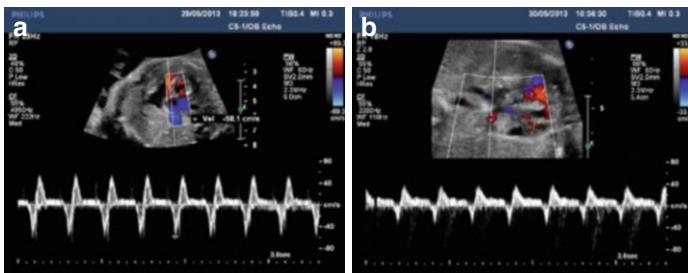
Doppler tracing of the pulmonary veins pre- and post-fetal atrial septostomy in a fetus with hypoplastic left heart syndrome and almost intact interatrial septum. (a) Pre-intervention assessment. Bidirectional flow in the pulmonary vein with high reversal flow velocity (58 cm/s) during atrial contractions (negative wave below the baseline). (b) Post-intervention assessment on the following day. Triphasic flow pattern in the pulmonary veins (better diastolic filling) with improvement of the reversal flow velocity (less than 40 cm/s)
